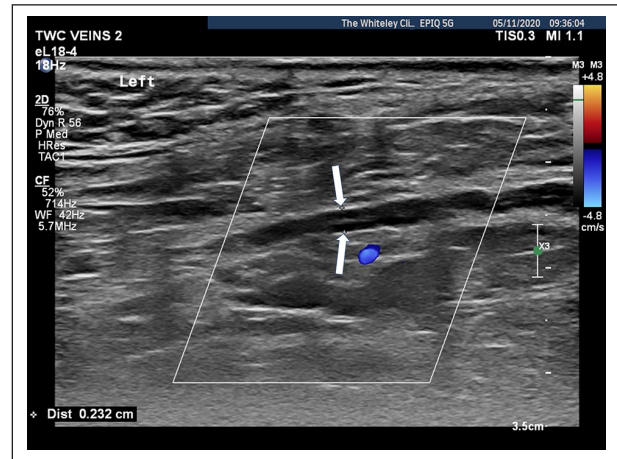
Duplex ultrasound showing thrombosed and left testicular vein with no flow (cursors showing reduced diameter of thrombosed vein shown by white arrows).
